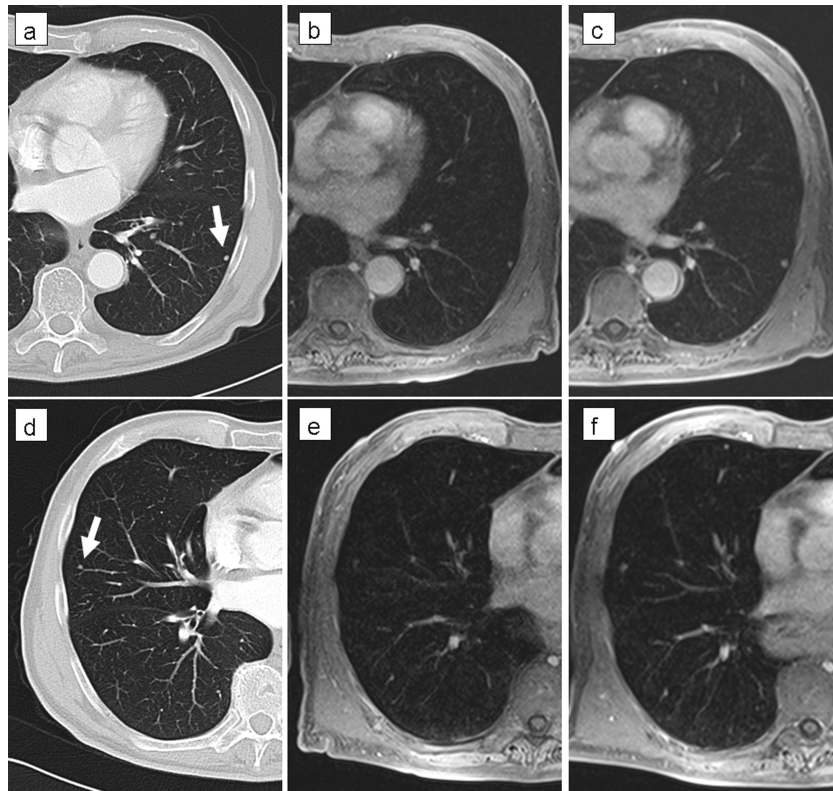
An example demonstrating the limitations of MRI for the detection of small lung nodules: (a,d) Small pulmonary metastases of a malignant melanoma in a 62-year-old patient (5 mm slices of a standard helical CT scan). (b,e) MRI of the corresponding positions at the same time; (c,e) the follow-up MRI after 3 months (the contrast-enhanced transverse 3D-GRE (VIBE) images were obtained as part of a whole body study; TR/TE 3.15/1.38 ms, TA 20 s, +FA 8°, FOV 350×400 mm, slices 72/4 mm). The clearly visible 3 mm nodule in the left lower lobe ((a) and (b); marked with an arrow on (a)) grew to a diameter of 5 mm within 3 months (c). Another 3 mm nodule in the lateral right middle lobe (marked with an arrow on (d)) is hardly visible on the corresponding MRI due to cardiac pulsation, but becomes clearer in the follow up study after growing to 4–5 mm (f).
